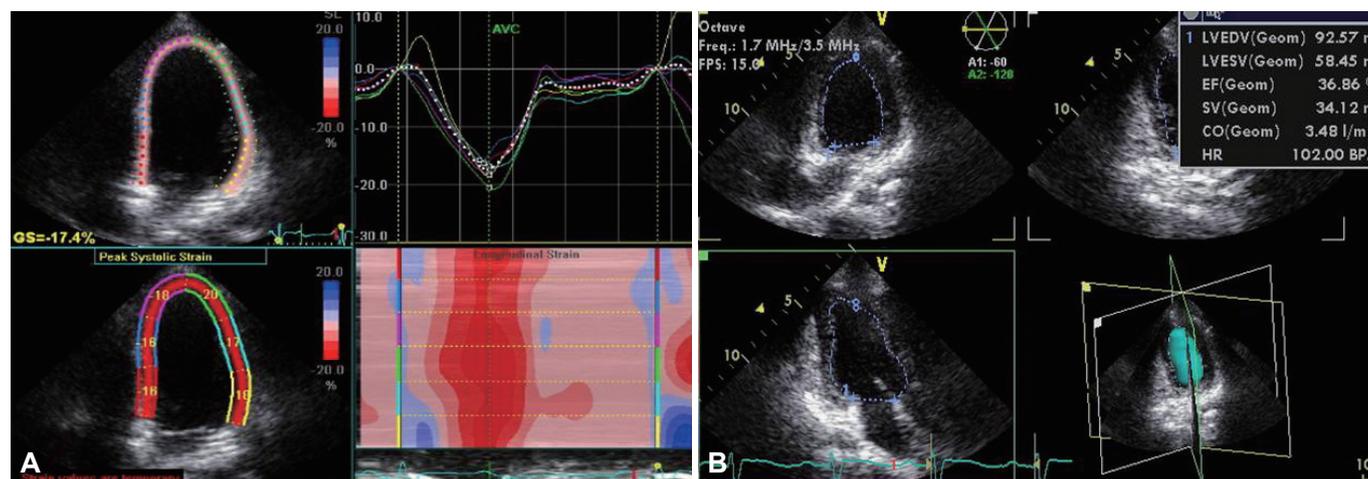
Left ventricular (LV) peak longitudinal strain and 3-dimensional LV volume measurement. A: LV peak global longitudinal strain at the apical 4-chamber view, which was -17% in 1 patient. B: 3-Dimensional LV volume measurement and acquisition of ejection fraction by tri-plane volumetry, which was 36.8% in 1 patient.
